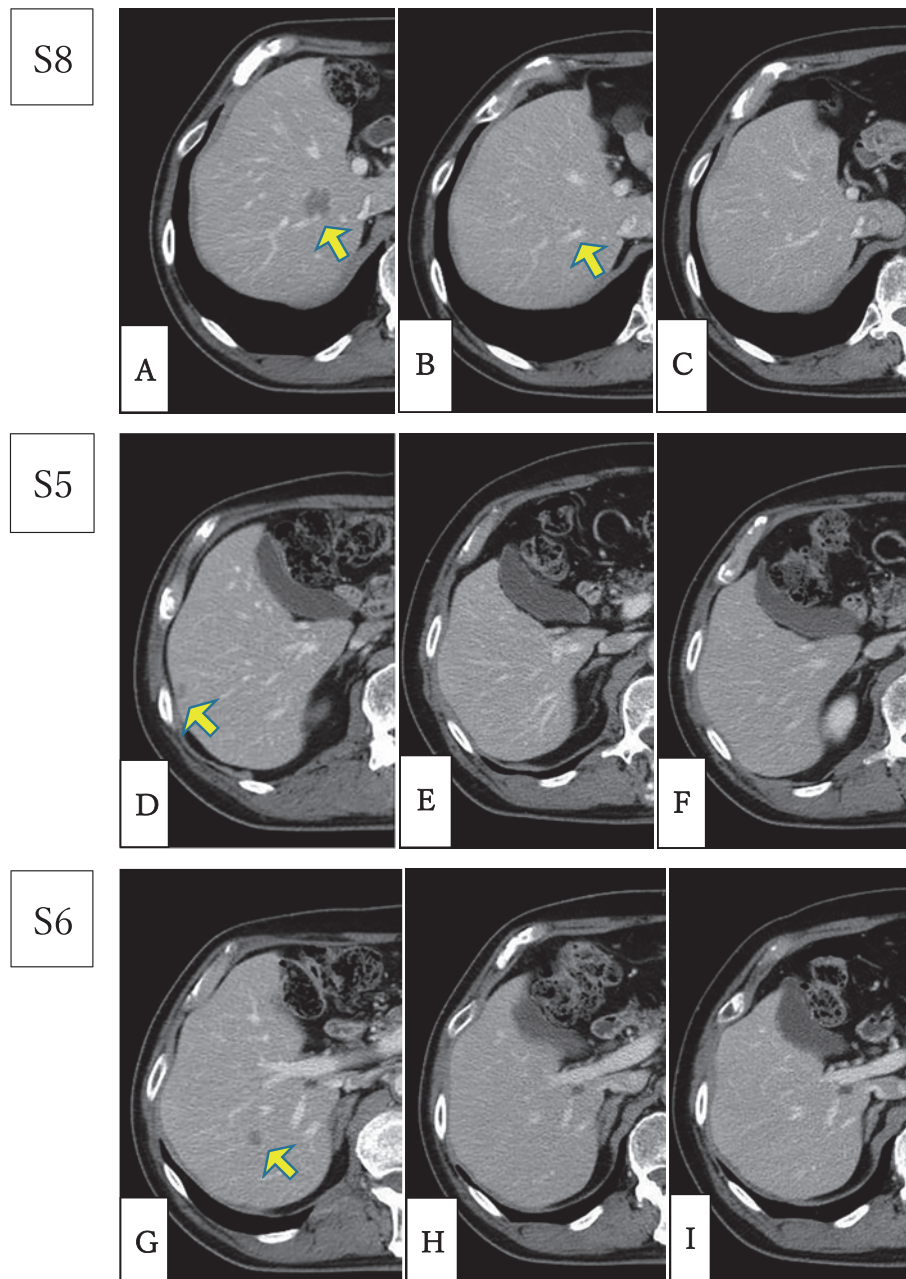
Image of an abdominal contrast-enhanced computed tomography scan. Computed tomography scan revealed liver metastases before surgery (A, D, G), after chemotherapy (B, E, H), and at 48 months after surgery (C, F, I) in S8 (A, B, C), S5 (D, E, F), and S6 (G, H, I) (arrows). All tumors had diminished (B) or disappeared after treatment (E, H), and the patient did not experience recurrence (C, F, I).
